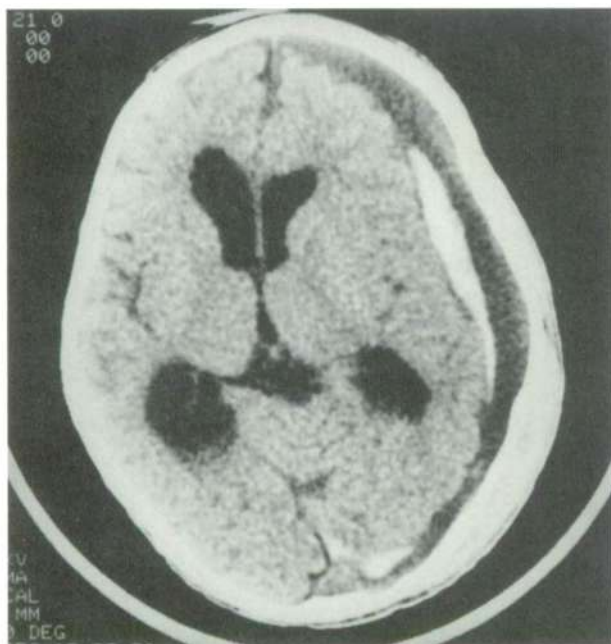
Computed (CT) scan showing large chronic blood clot. The dark portion of the clot is older, partially liquefied blood. The white area within the clot is caused by fresh blood in this space.
